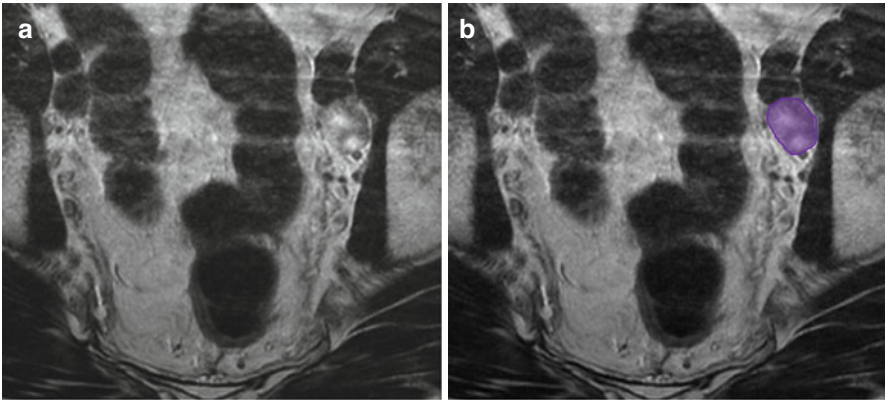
(a, b) Axial T2-weighted image in a patient with anal cancer shows metastatic left external iliac lymph node (*purple*)
